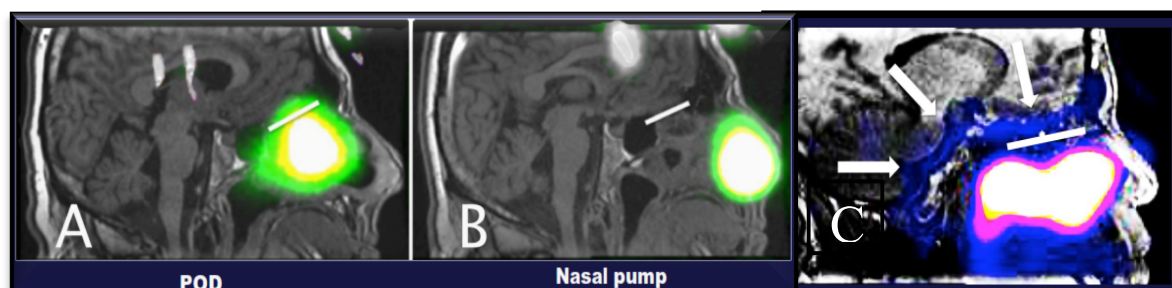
2D SPECT image showing deposition of radiolabelled tripeptide using Impel Inc.'s Precision Olfactory Delivery (POD) device (A) versus traditional nasal pump (B). Cribriform plate that is where the nasal cavity meets the CNS is denoted by a white bar. (C) 3D SPECT image showing deposition in the olfactory bulb and cerebellum/brainstem (marked by arrows) indicating direct nose-to-brain delivery [123,124]
